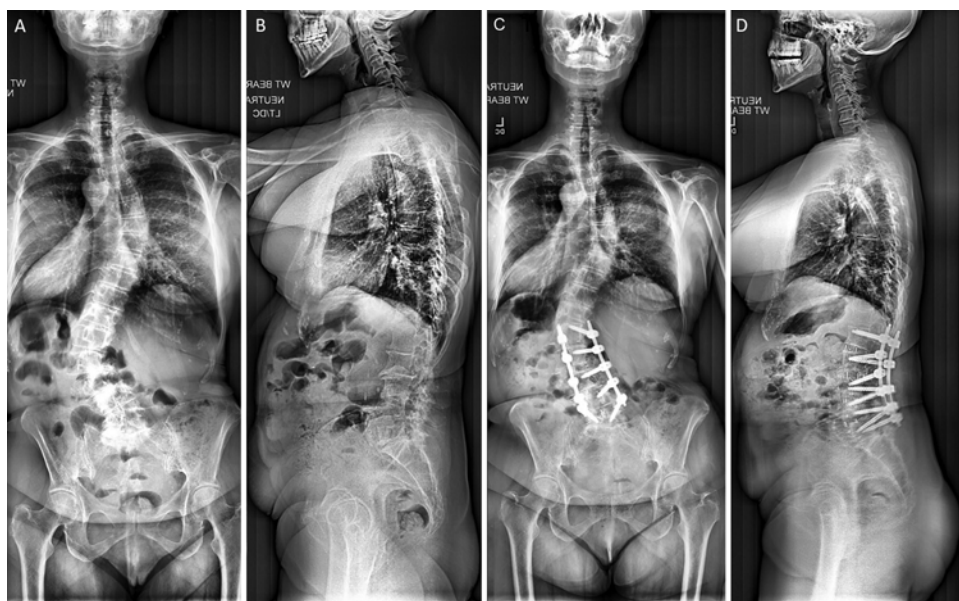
A and B: Preoperative AP and lateral upright scoliosis radiographs. C and D: Postoperative AP and lateral upright scoliosis radiographs after L1–5 LLIF with posterior percutaneous pedicle screw instrumentation.
